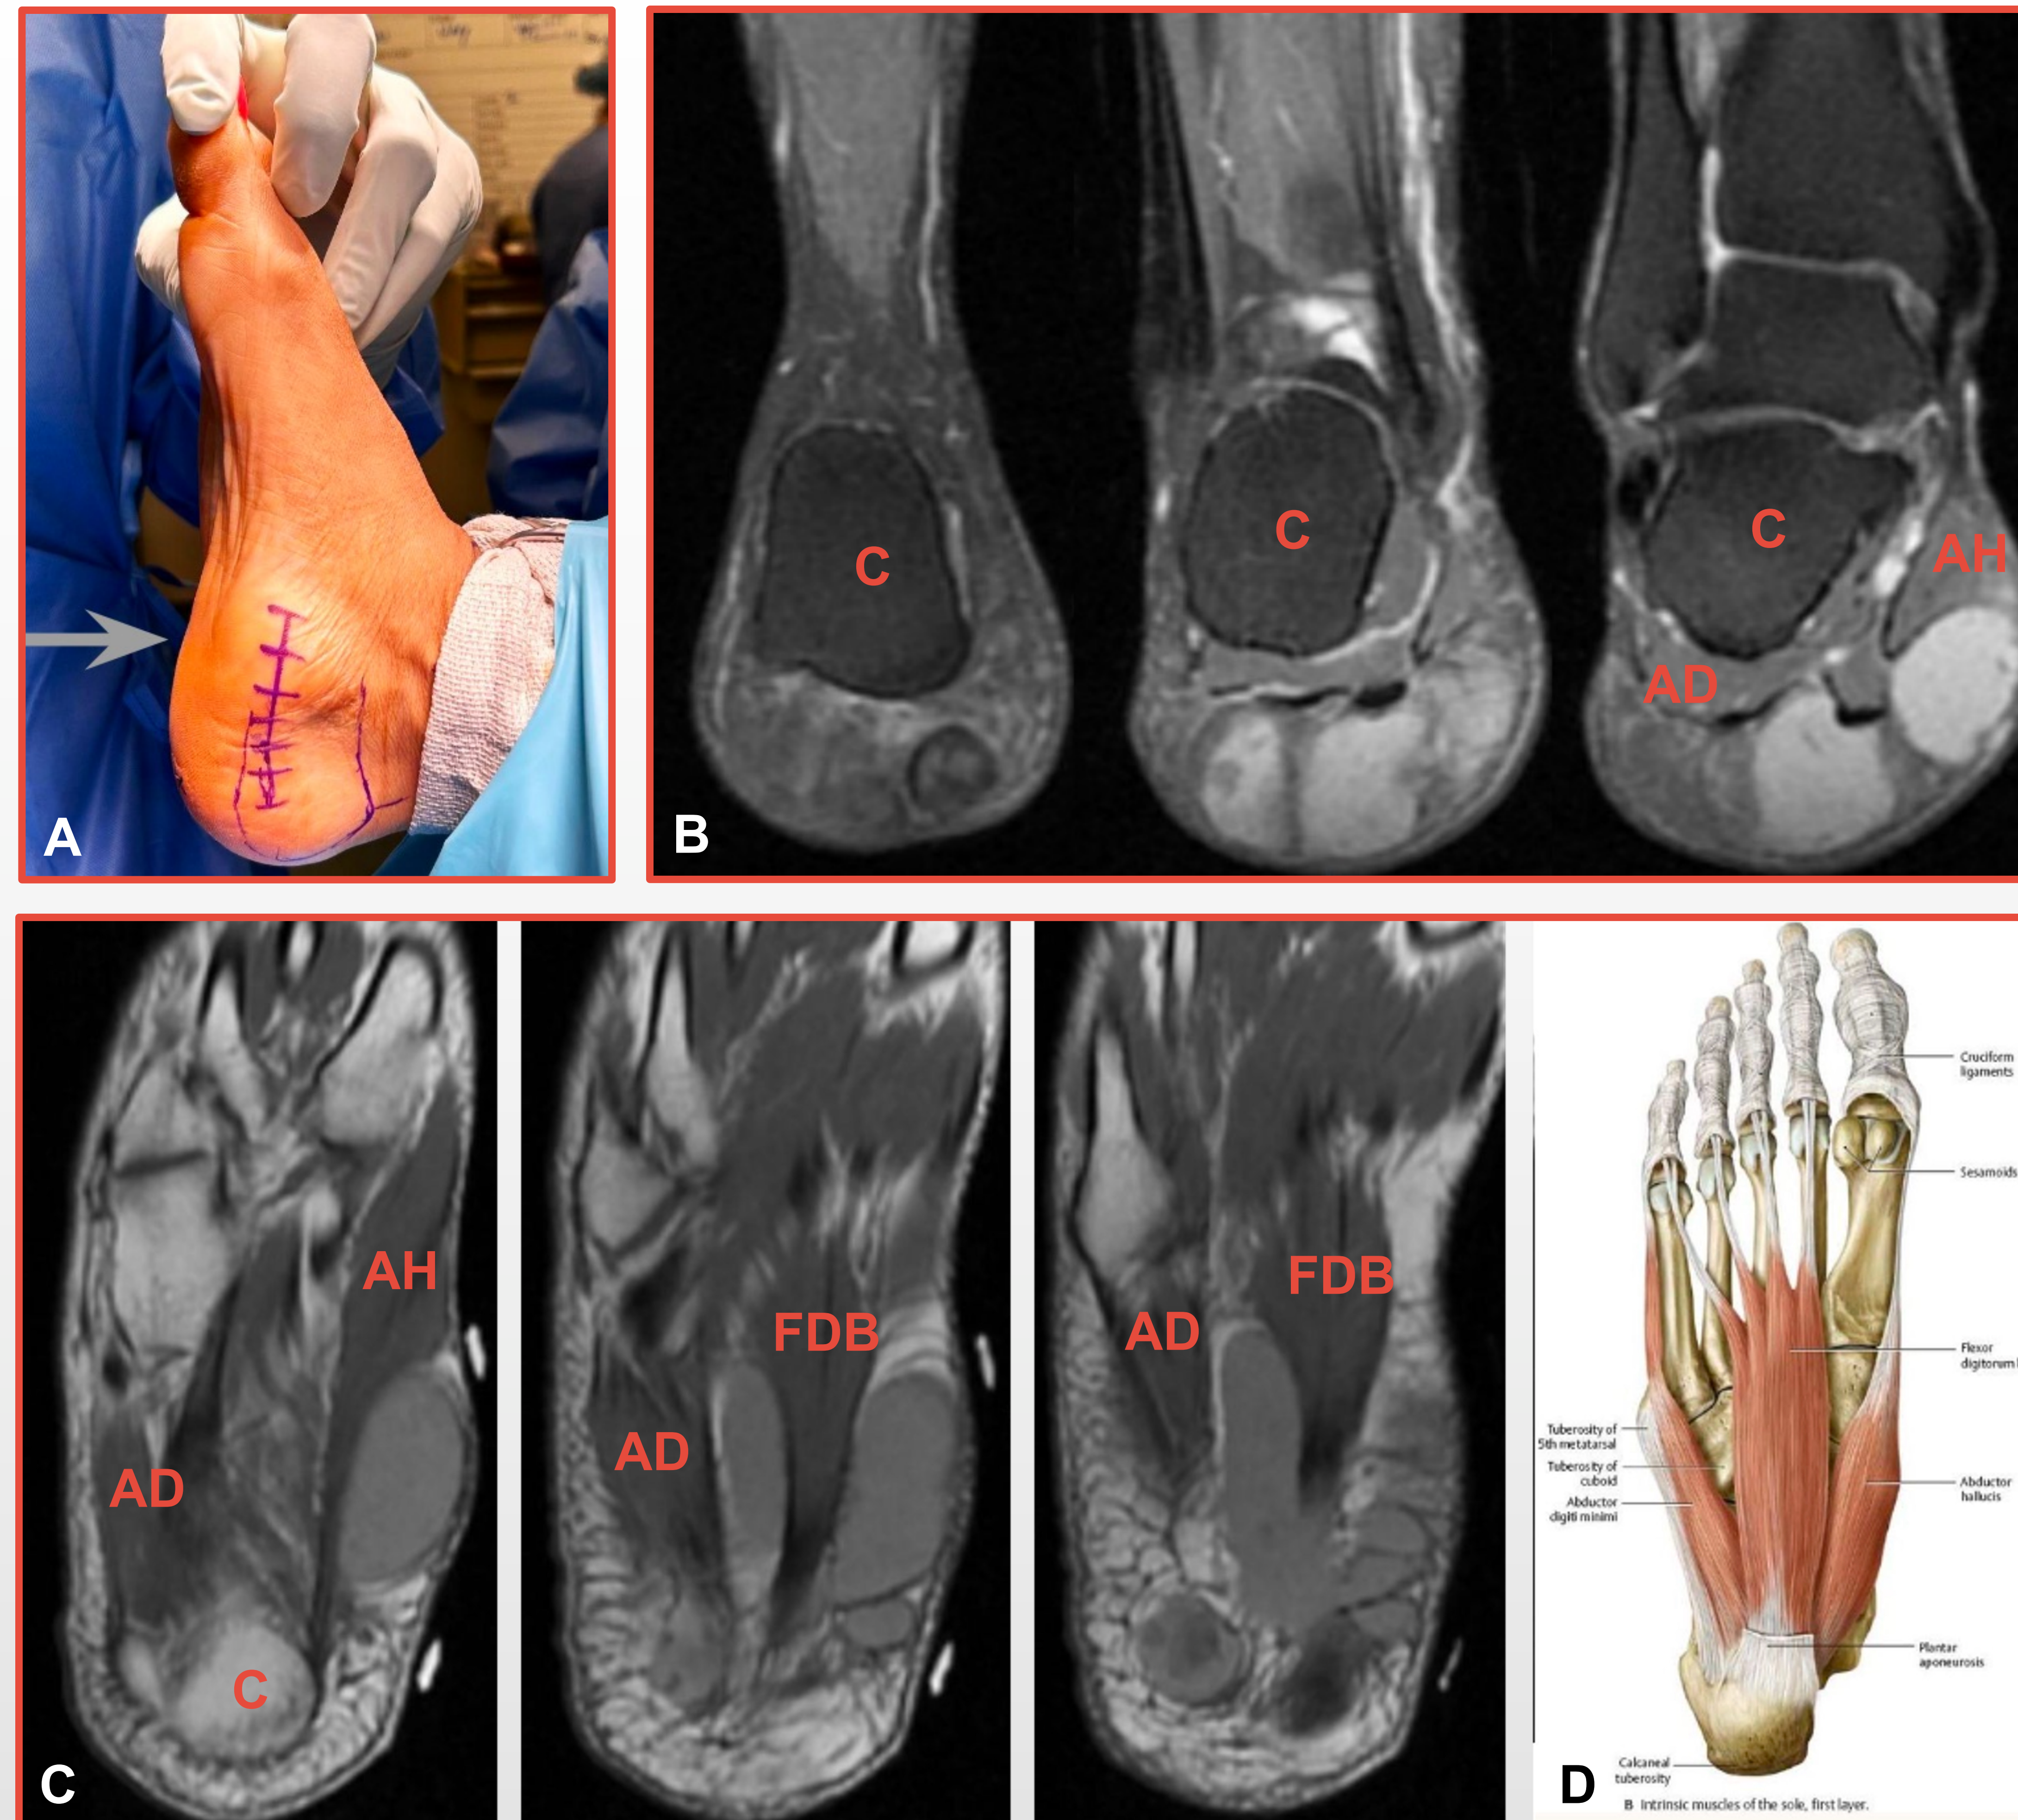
A clinical picture (A) is displayed above. Coronal (B) and Axial (C) MRI cuts are displayed with labeled anatomical structures including the calcaneus (C), abductor hallucis (AH), flexor digitorum brevis (FDB), and abductor digiti minimi (AD) muscle bellies. For reference an anatomical rendition of the first muscular layer of the plantar foot is attached (D).
